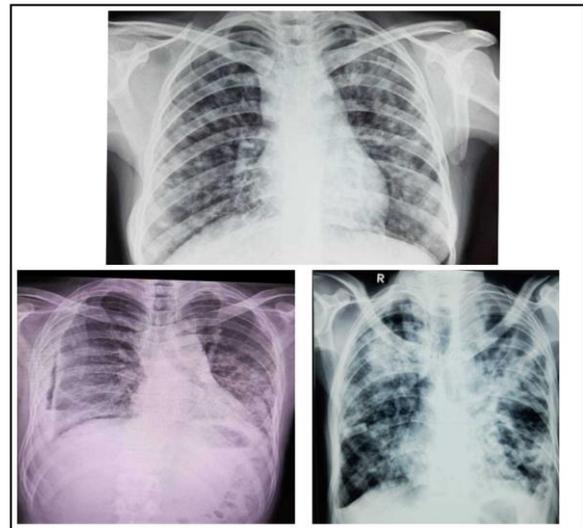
Chest radiography images showing patterns of involvement in TB and COVID patients.
